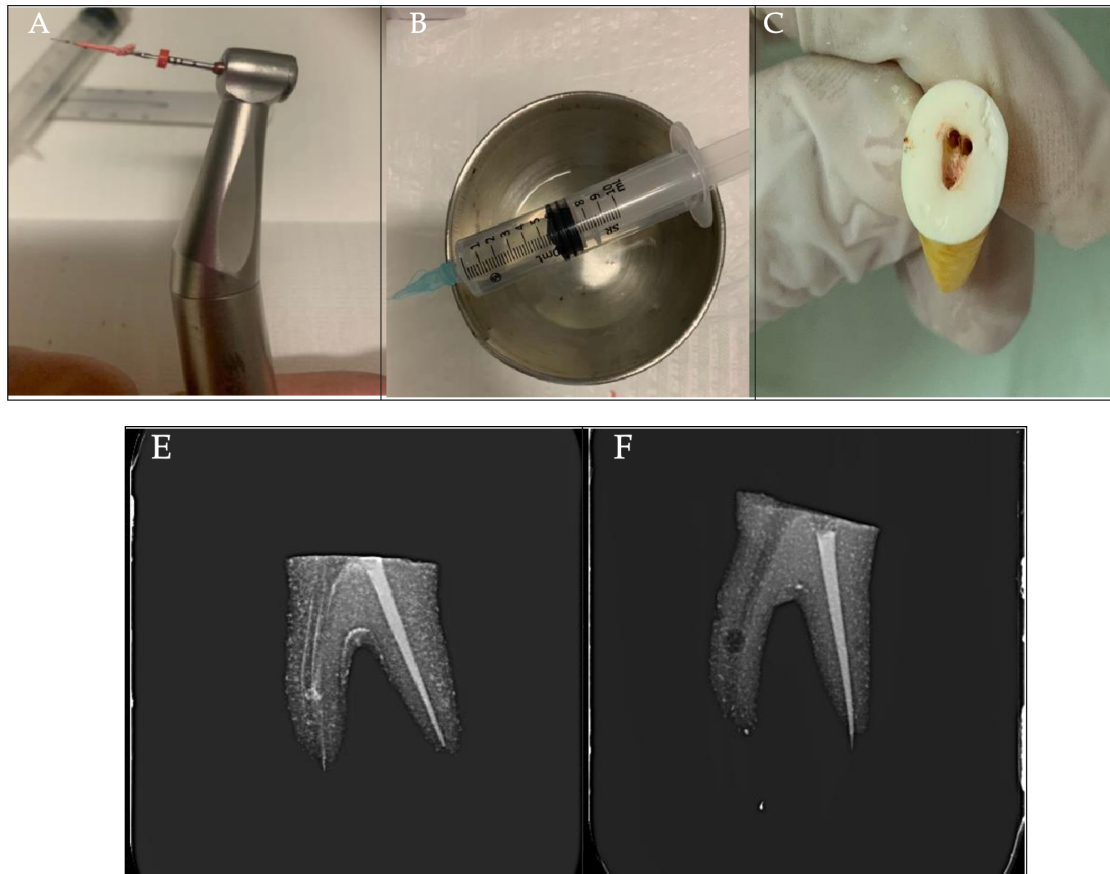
Standardization of the working length (A- unit being cut / B - standardization of 16 mm of the mesial root). Retreatment (A- Gutta percha removed / B- Hypochlorite 2.5% / C- Clinical view after retreatment. Final radiography ((E- unit imaged with Reciproc #R25 file (VDW - Germany) / F - unit imaged with V-File #R25 file (TDK - Brazil)). Periapical x-ray before and after retreatment.
